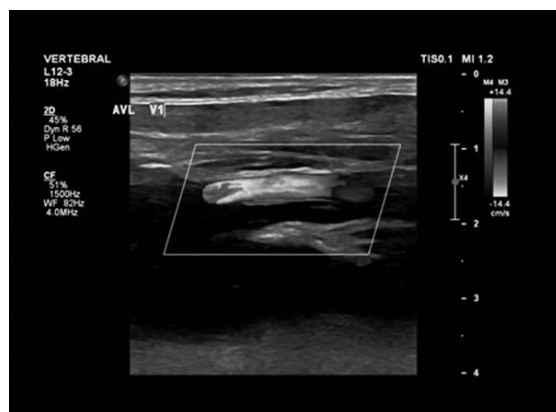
Neurovascular ultrasound showing hematoma in V2 segment in left vertebral artery
